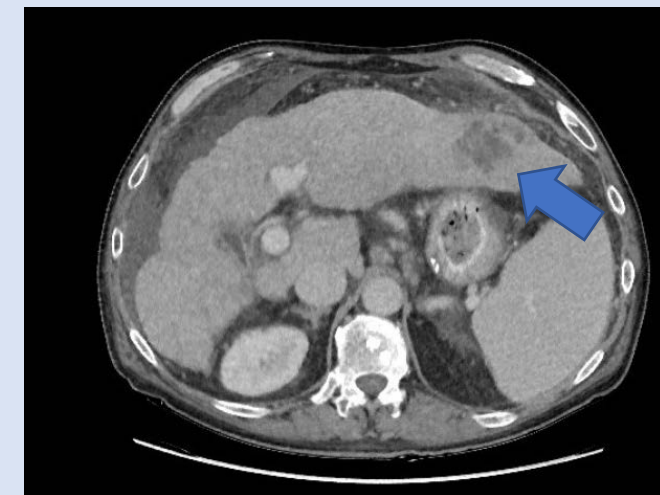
CT scan of patient 2 demonstrating liver abscess in segment II
